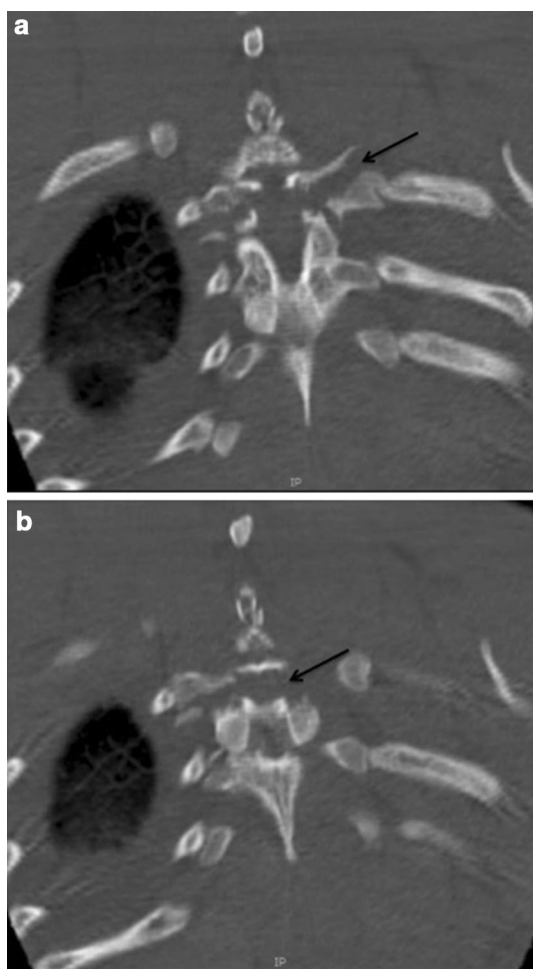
CT coronal reconstruction showing the split of the pedicles and transverse processes (a black arrow) and the lamina (b black arrow)
